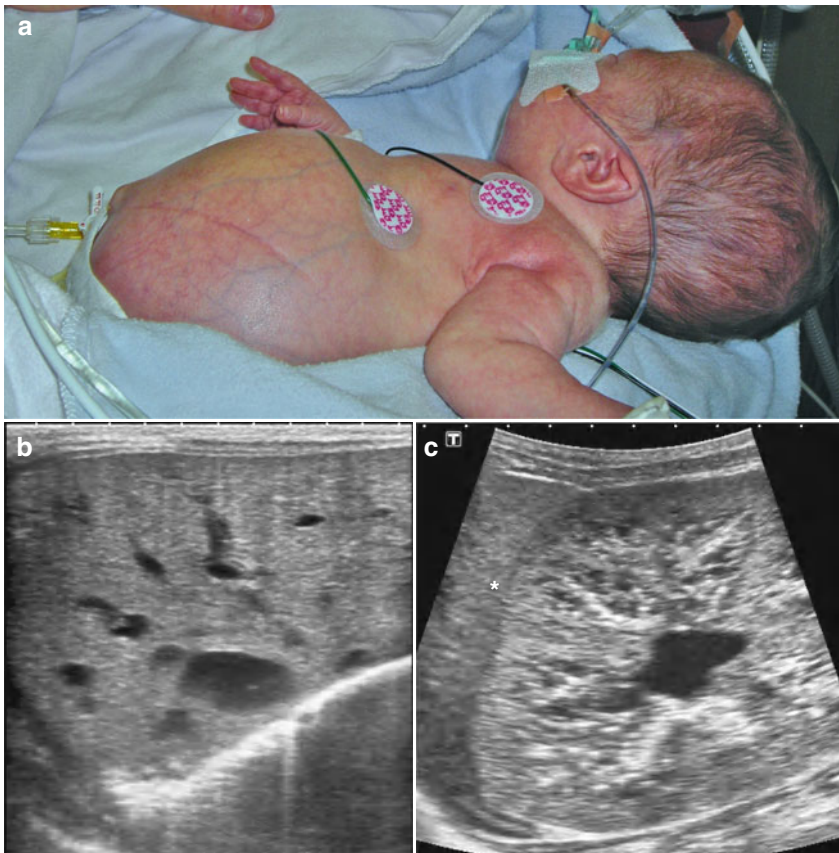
Infant with ARPKD. (a) Protruding abdomen due to hugely enlarged kidneys. Ultrasound images on the third day of life. (b) Liver shows dilatation of the intrahepatic biliary tree with cystic components (Caroli type of appearance). (c) Right kidney: bilateral loss of corticomedullary differentiation; the renal parenchymal echogenicity exceeds that of the liver located cephalad (to the left) of the kidney (*); multiple tiny cysts of 1–2 mm diameter are seen throughout the renal parenchyma. The right kidney measured 7.4 cm and the left kidney 8.1 cm. Scale bar at the top of the ultrasound images (dots at 1 cm intervals)
